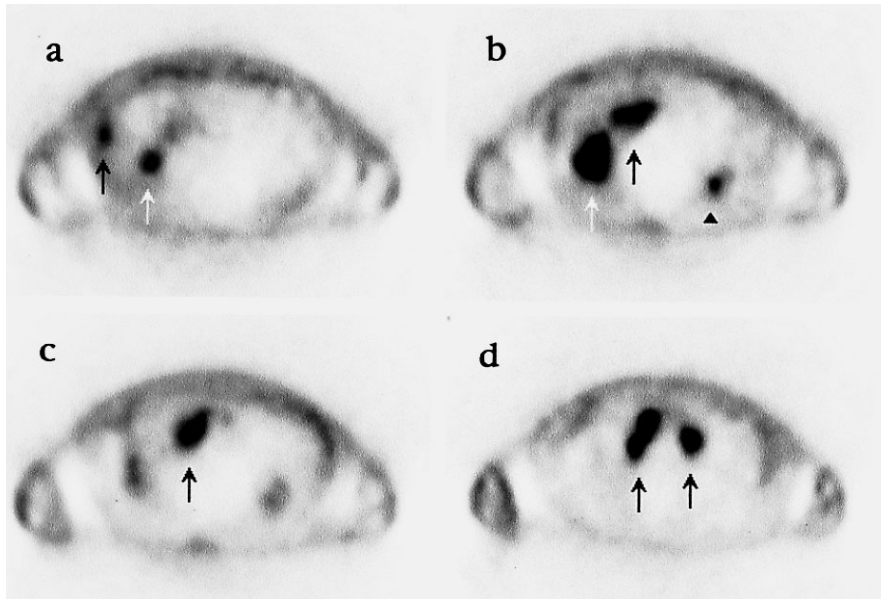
Axial images of ^{18}F -FDG PET obtained at same levels as A, B, C, and D respectively, revealed abnormal increased uptake of the right renal pelvic tumor extending to the renal cortex (white arrows in a and b) with liver metastasis (black arrow in a) and paraaortic lymph node metastases (black arrows in b, c and d). Physiological uptake of the left renal pelvis was shown (arrowhead in b).
